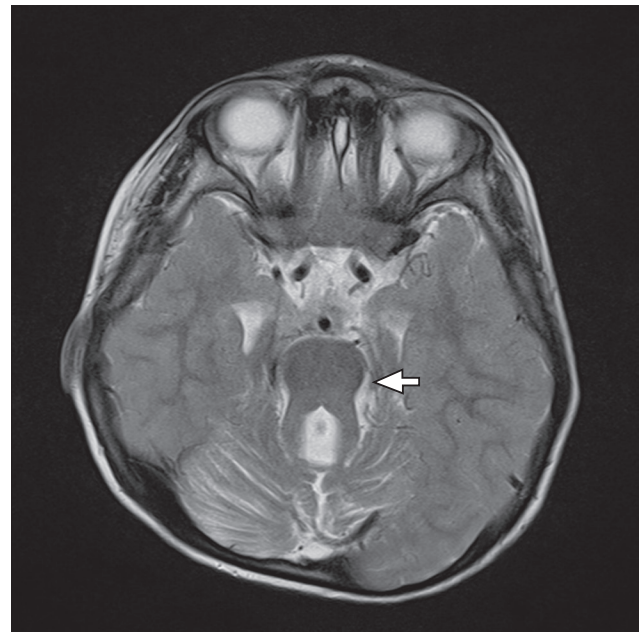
Brain magnetic resonance imaging showing the typical "molar tooth sign" attributed to cerebellar vermis hypoplasia and brainstem malformation.
